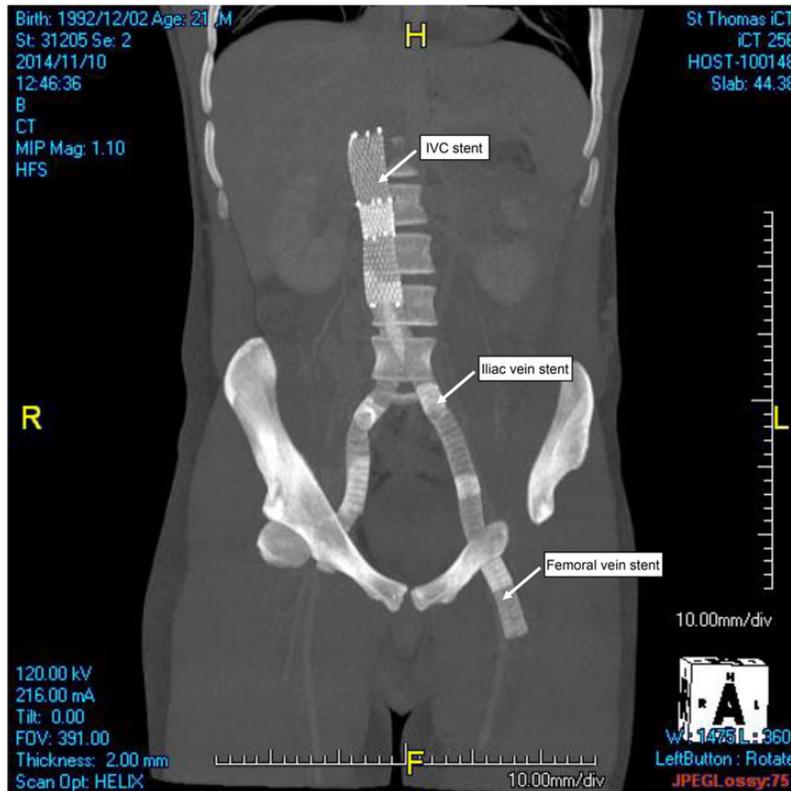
Deep venous reconstruction. Computed tomography with contrast showing total reconstruction of the deep venous system using venous stents following a previous extensive ilio caval DVT.
